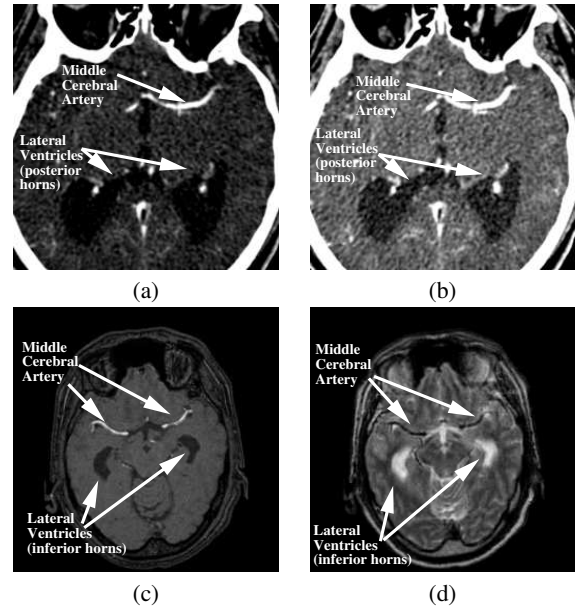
Upper row: CT axial slice with the posterior horns of the lateral ventricles and middle cerebral artery with two contrast windows (a, b). Lower row: MRI axial slice with the inferior horns of the lateral ventricles and middle cerebral artery (left and right). (c) MRI angiography sequence, (d) MRI TSE sequence¹⁶.
